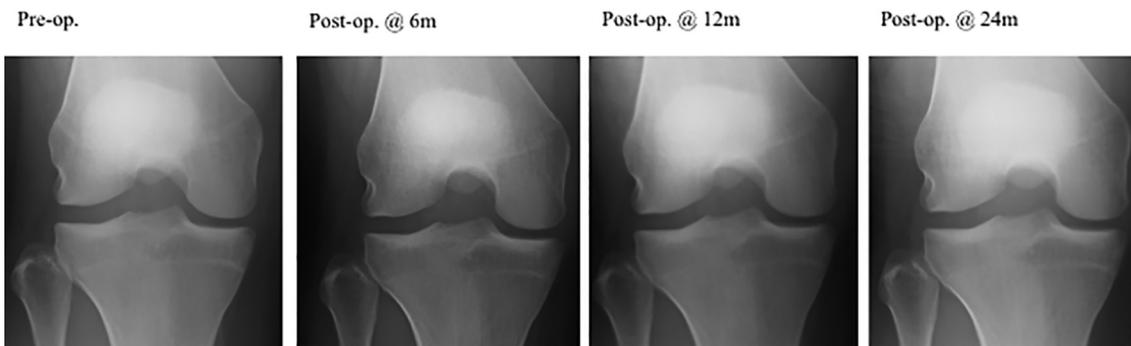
The radiographic findings with posteroanterior 45° flexed weightbearing view for Case 2 pre-operatively and postoperatively at six, 12, and 24 months. There was no change in lateral joint space, no osteophyte formation, and no subchondral bone sclerosis. Pre-op. = preoperative; Postop. = postoperative; m = month.
